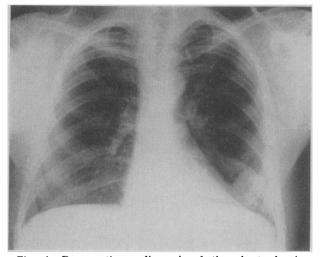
Preoperative radiograph of the chest showing an ill-defined opacity in the lower part of the left lung field, lateral to the cardiac shadow.
